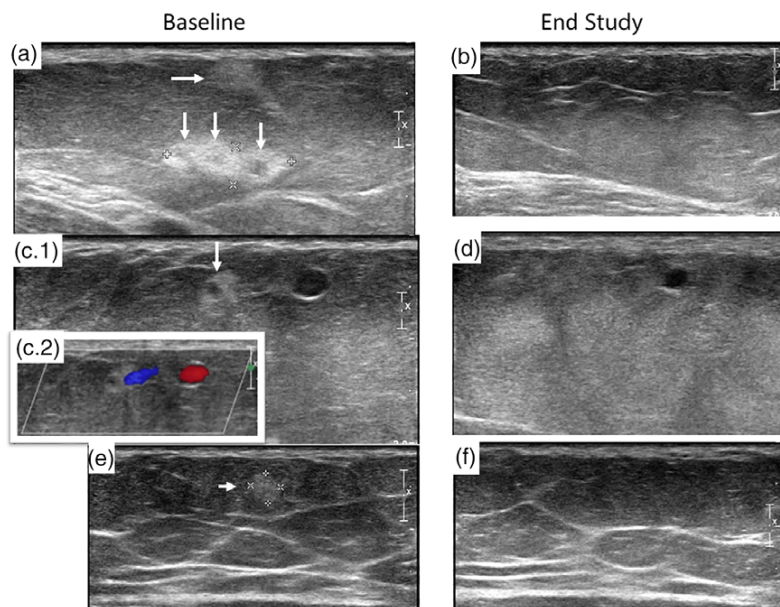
Hyperechoic nodules in three different participants before and after subcutaneous adipose tissue therapy. All ultrasound pictures have skin at the top (white lines). (a) Subject 1: right transverse calf with three hyperechoic nodules (arrows) at baseline. (b) Subject 1: right transverse calf end study shows loss of three nodules. (c.1) Subject 2: nodule just under skin (arrow) and to the left of a vessel (rounded hypoechoic area) at baseline in right anterior thigh. (c.2) Subject 2: colour Doppler flow demonstrates hyperechoic nodule surrounds a vessel (blue) to the left of the larger vessel (red) at baseline in right anterior thigh. (d) Subject 2: nodule to the left of the vessel at end study right anterior thigh no longer be found at end study. (e) Subject 3: single hyperechoic nodule in right anterior thigh (arrow) at baseline. (f) Subject 3: right anterior thigh end study shows loss of nodule. [Colour figure can be viewed at wileyonlinelibrary.com]
